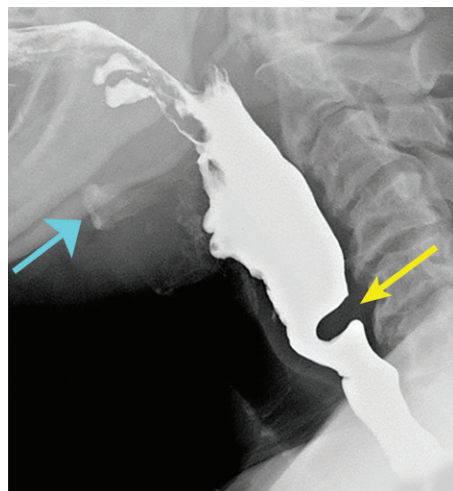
Diminished opening of the PES in a 44-year-old woman with gastroesophageal reflux. Lateral radiograph of swallowing shows a transverse filling defect in the posterior wall of the PES, called the CP bar (yellow arrow), when the hyolaryngeal complex is fully elevated (blue arrow). The luminal narrowing obstructs the passage of the bolus and distends the proximal pharyngeal lumen.
